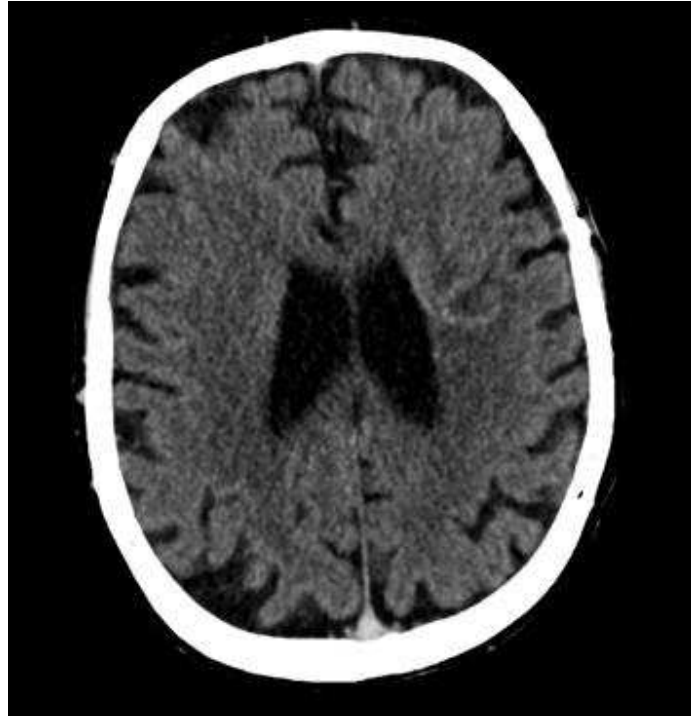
Contrast enhanced CT head at a) day 0 and b) 6 months.
